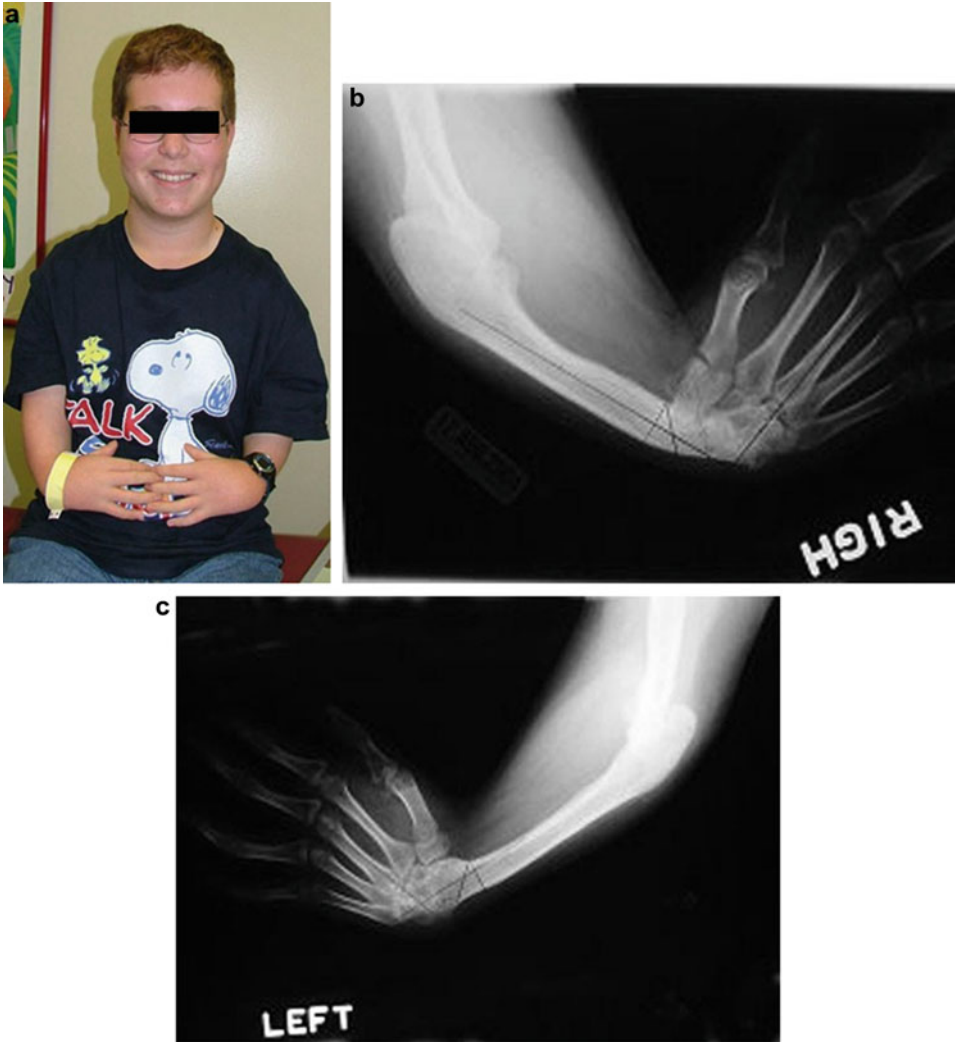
(a–c) A 14-year-old boy with TAR syndrome showing similar clinical (a) and radiographic (b, c) features
